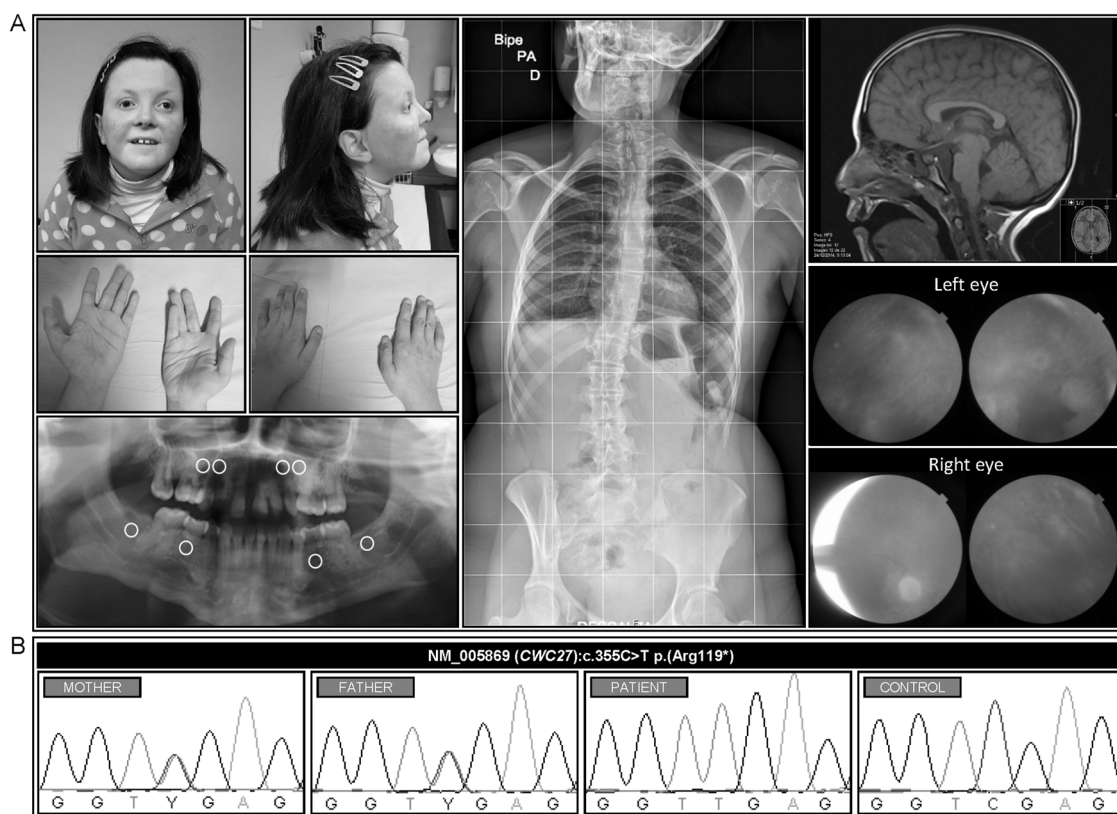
a Clinical features of patient. White circles in the orthopantomography indicate the location of dental agenesis at 14 years of age. Authors have obtained consent to publication of the images. b Sanger
